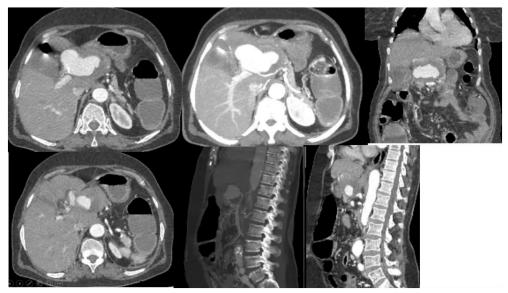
CT angiogram showing a saccular aneurysm of the hepatic artery, partially thrombosed, with no evidence of rupture.
